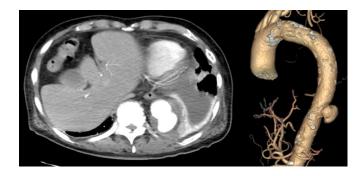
Computed tomography scan showing a 47-mm mycotic saccular aneurysm in the descending aorta.
